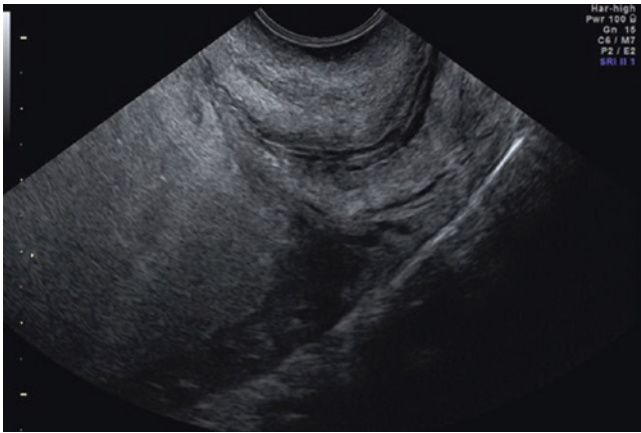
Transvaginal ultrasound: complete placenta previa (major previa)
